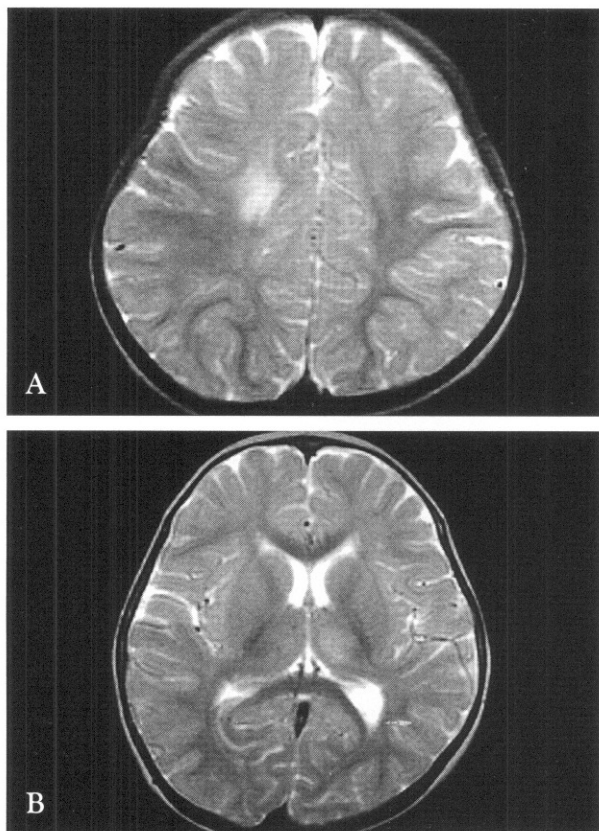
T2-weighted axial MRI image revealed diffuse increased signal intensity in periventricular white matter of frontal lobe, right (A) and thalamus, left (B).
